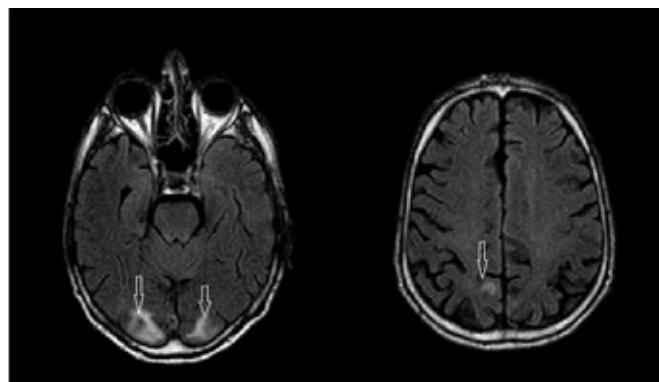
FLAIR sequences axial MRI revealed hyperintense areas in medial cortex of bilateral occipital lobes and the subcortical white matter extending partly into parietal region (indicated by arrow).
